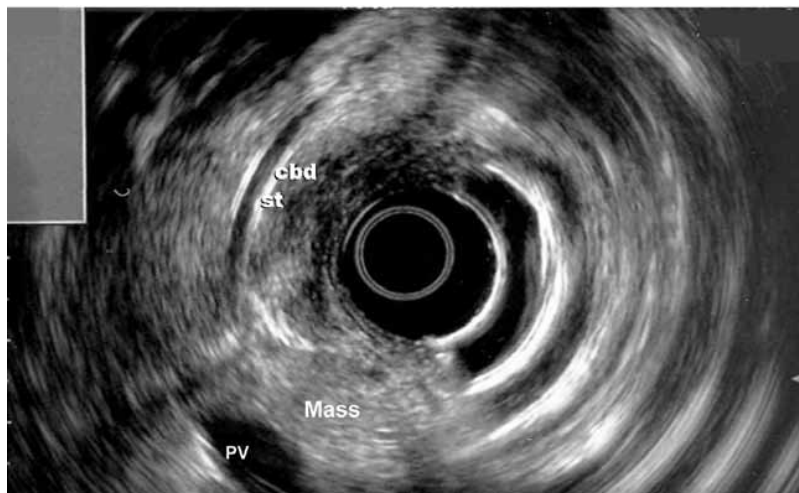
Endoscopic ultrasound showing a heterogeneous isoechoic mass abutting the portal vein (PV) and common bile duct (CBD). A stent (st) is also present.
